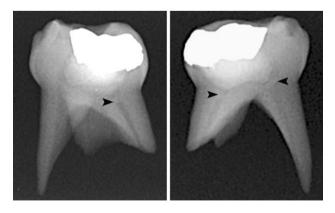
Conventional radiographs demonstrating calcific bridges (*black arrowhead*) between radicular pulp and pulp capping biomaterial (CEM cement)
